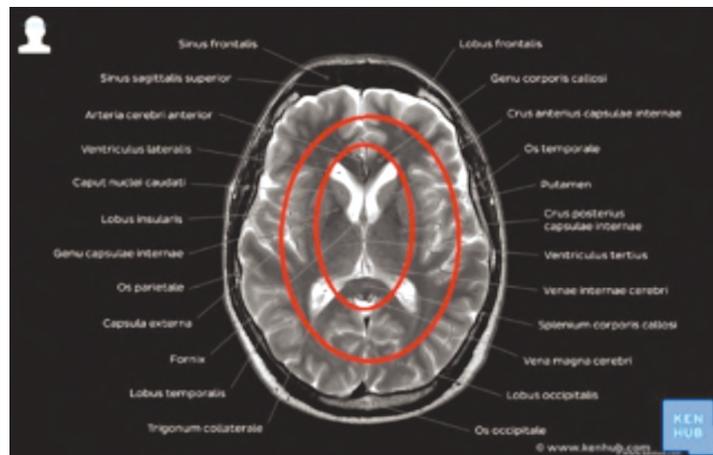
Axial MRI brain showing zone classification.
